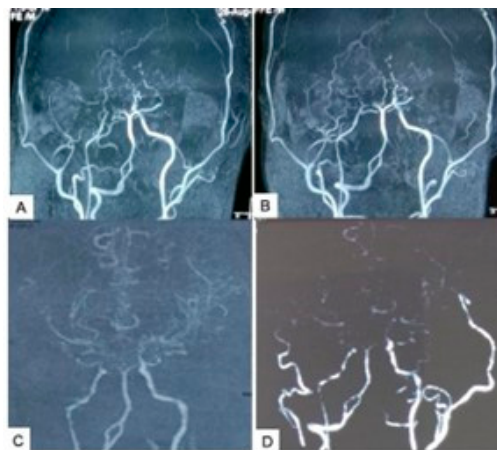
(A,B) Preoperative CTA of the brain in an adult with bilateral symptomatic MMD; (C,D) postoperative CTA on the first POD showing a direct STA-MCA bypass with increased parenchymal vascularity. Source: Figure by authors.
